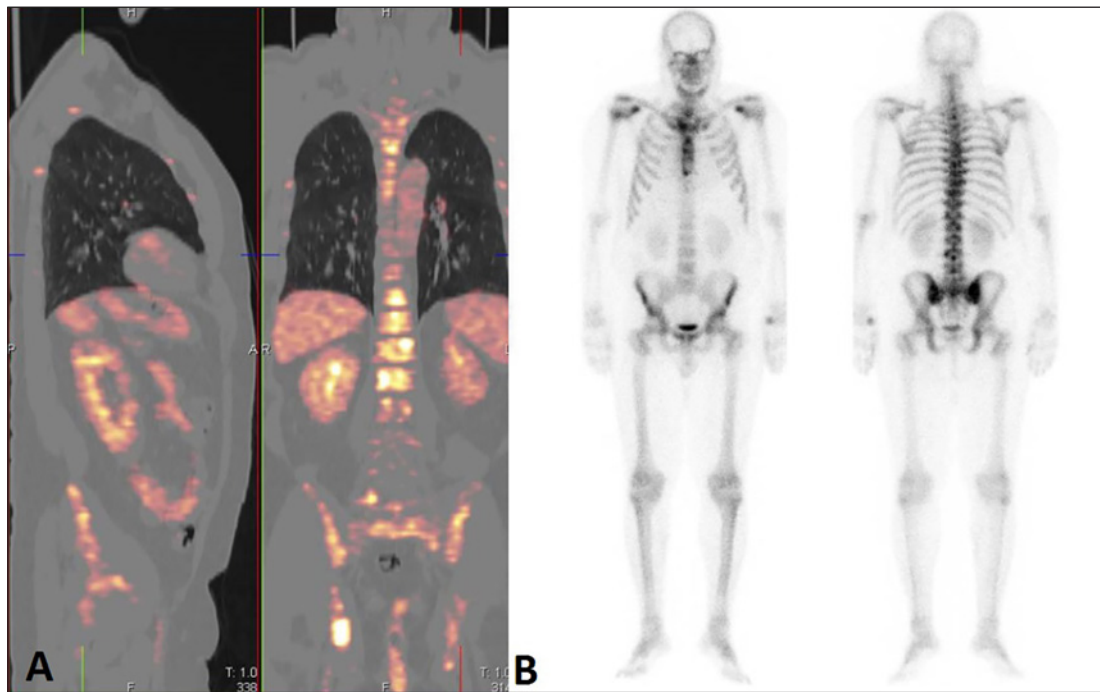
A PET scan showing an uptake at different vertebral levels. B Negative bone scintigraphy.
